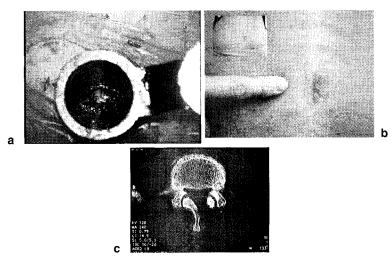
a Intraoperative view of METREX. b Lumbar disc hernia can be performed via just one finger skin incision and split the muscle. c Postoperative computed tomography of unilateral approach for lumbar canal stenosis
